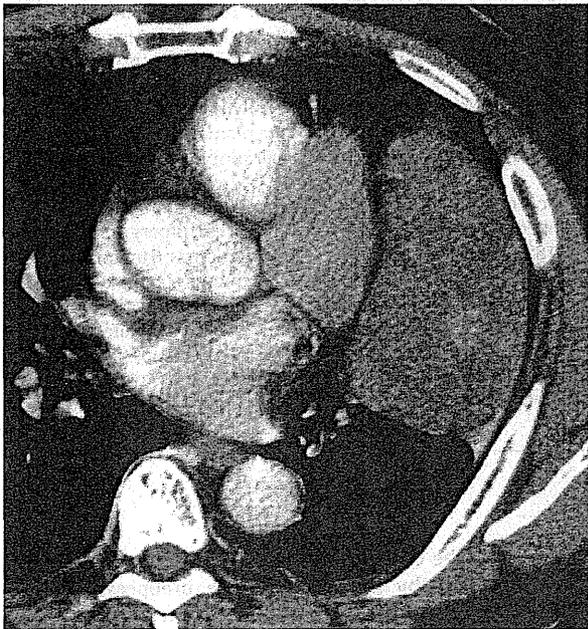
Contrast-enhanced computed tomography demonstrated a well-circumscribed, smooth and inhomogeneous mass in the left thorax.
